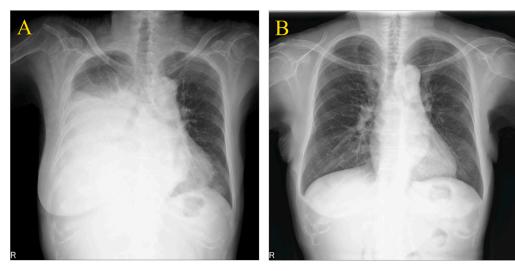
Chest radiographic examination. (A) Massive pleural effusion on the right side at the first visit was observed. (B) Pleural effusion disappeared after closure of the fistula.
